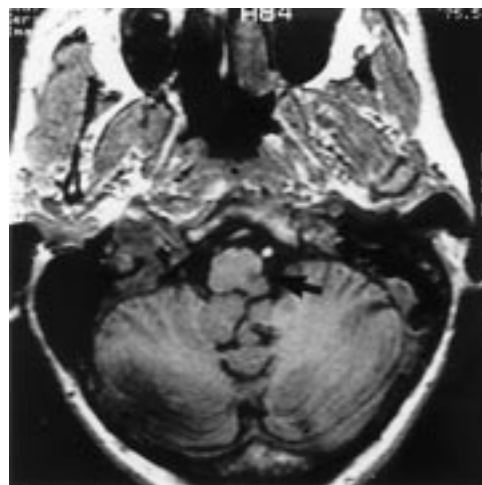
An axial MRI through the upper brainstem and cerebellum (SPGR, data acquisition method No 3—see methods) from patient 6. A small, low density lesion is shown just deep to the left lateral surface of the rostral part of the medulla oblongata, between the olive and inferior cerebellar peduncle (arrow); it was visible on three contiguous images, giving it a longitudinal extent of about 4.5 mm. The high signal in the left vertebral artery adjacent to the olive is produced by flowing blood and is a normal signal for this type of data acquisition.
